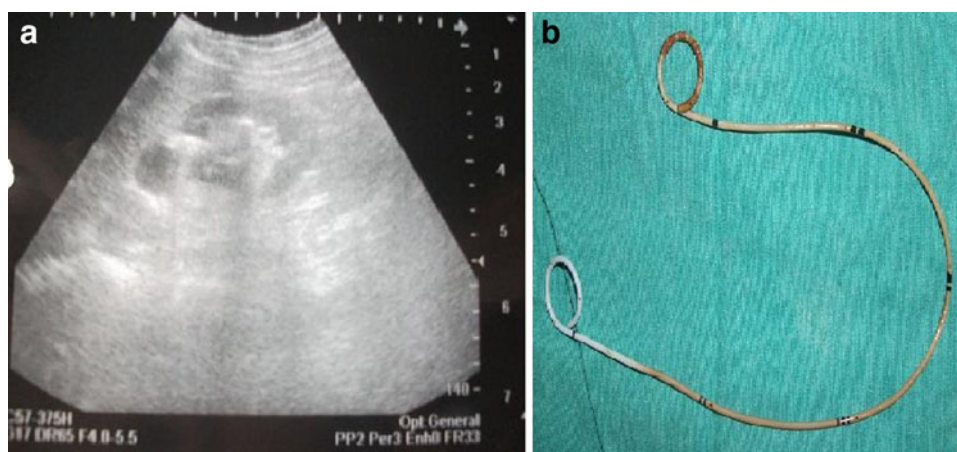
a Ultrasonographic appearance of a 20 months forgotten stent in a pregnant woman. b Stent was removed at 21-week of pregnancy
